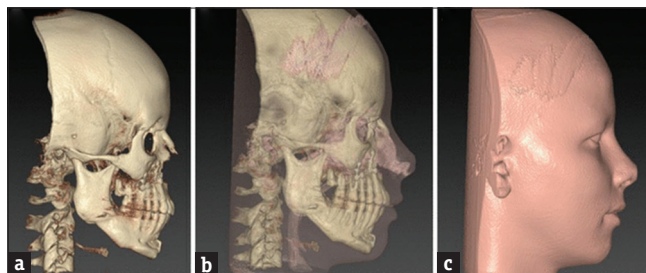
(a) CT image of Craniofacial structure (b) processing for Facial reconstruction (c) Facial reconstruction done
